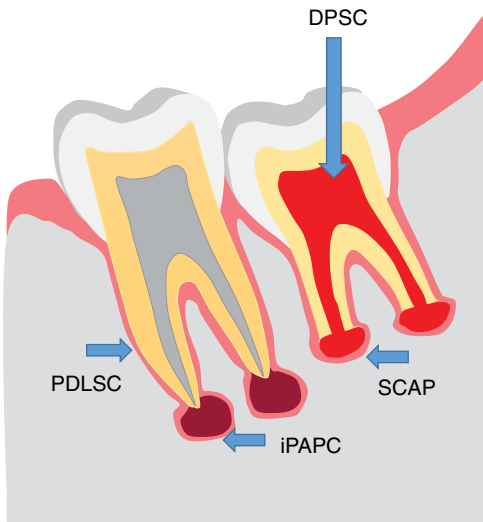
Stem cell types relevant for regenerative processes in the pulp and periapex. BMSC: bone marrow stem cells; iPAPC: inflamed periapical progenitor cells; DPSC: dental pulp stem cells; SHED: stem cells from human exfoliated deciduous teeth; SCAP: stem cells of the apical papilla. Modified from [38].
